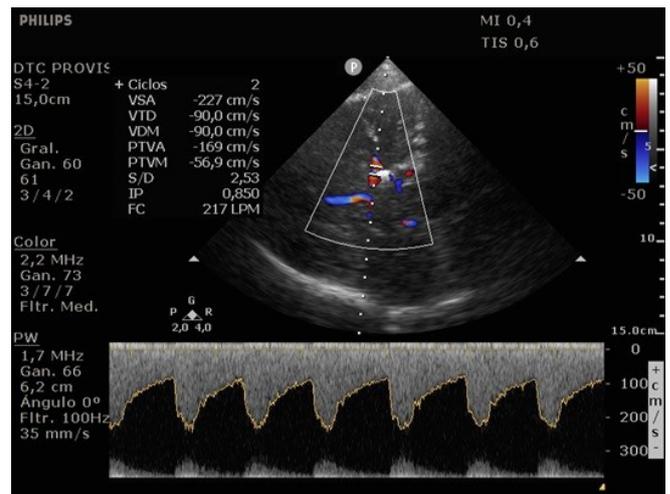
Transcranial ultrasonography of the anterior cerebral artery.
